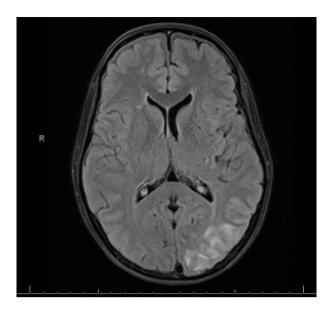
Cranial MRI showing a T2 hyperintense signal in the cortico-subcortical region of the left parieto-occipital lobes.
